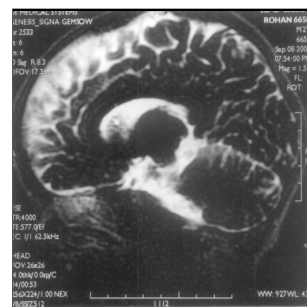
MRI sagittal view showing subdural fluid collection, which occurred following meningitis.
